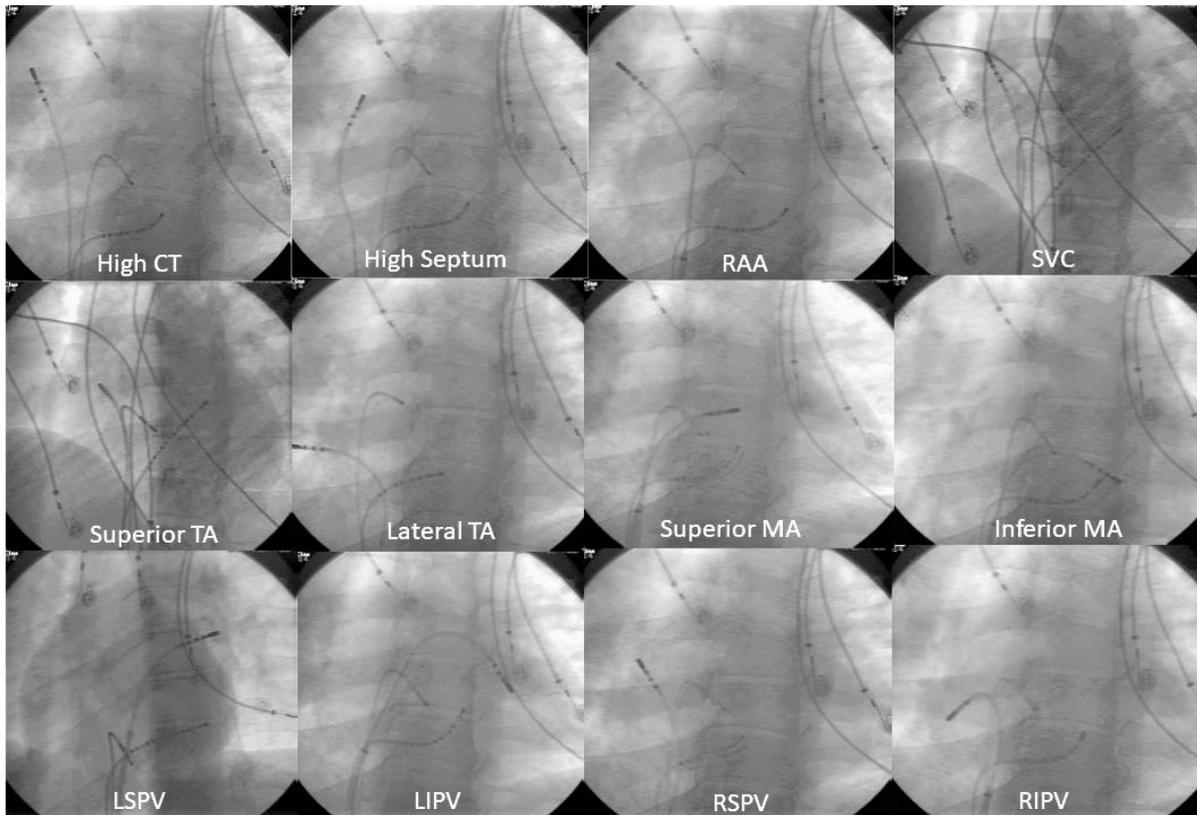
An LAO 30° fluoroscopic views of catheter positions for atrial pacing sites. Top panel (from left to right): high CT, high septum and RAA and SVC. Middle panel (from left to right): Bottom: SVC, superior TA, lateral TA, superior MA and inferior MA. Top panel (from left to right) : LSPV, LIPV, RSPV and RIPV.
